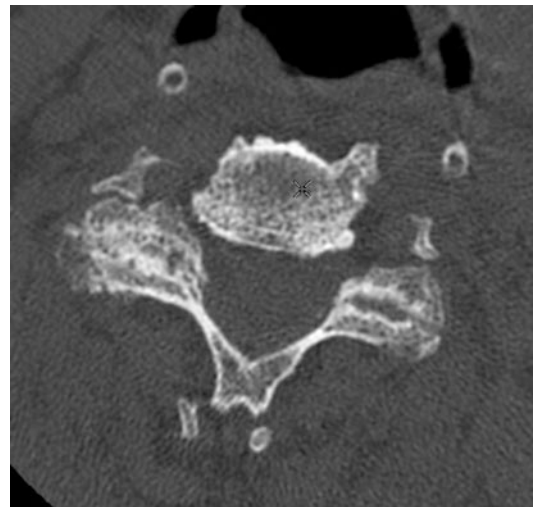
Axial CT image in an old man showing marked degenerative and osteoarthritic changes involving facet joints
